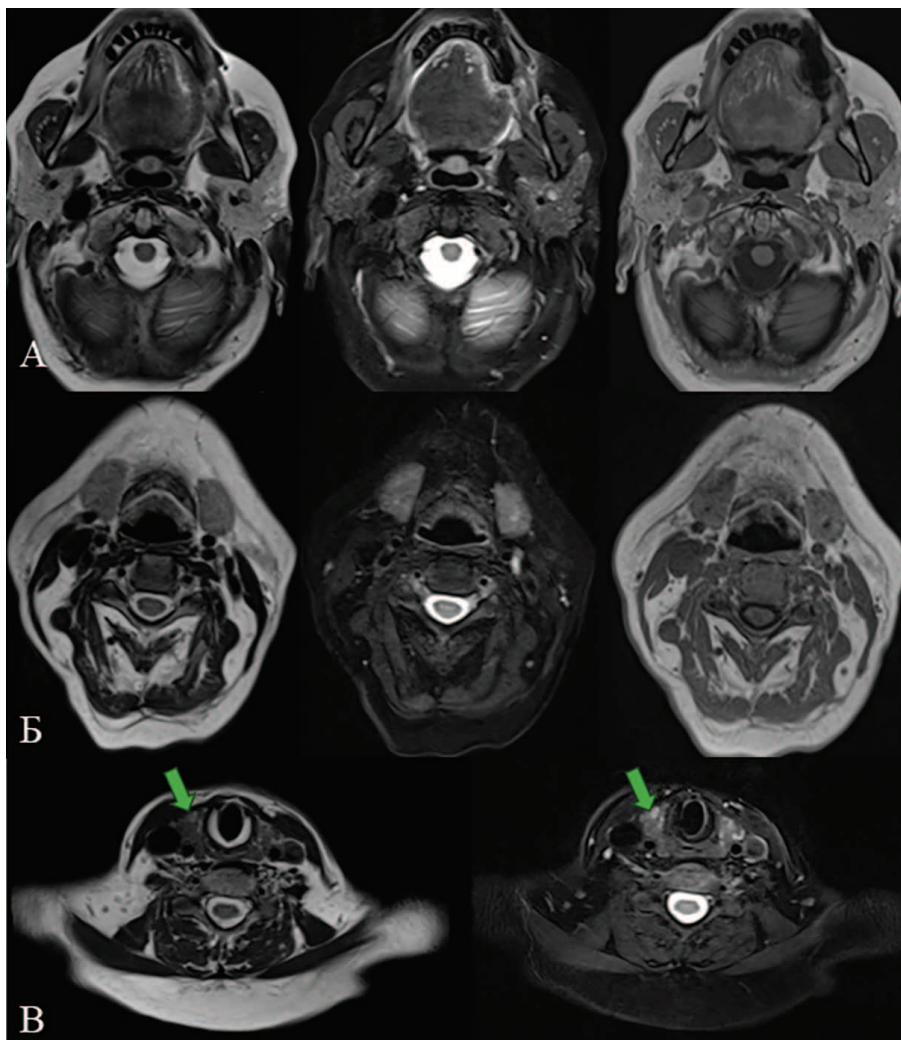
MRI of the soft tissues of the neck at the level of the parotid salivary glands (A), at the level of the submandibular salivary glands (B), at the level of the thyroid gland (C), T2-weighted image pulse sequences, T2-weighted image with signal suppression from fat tissue and T1-weighted image, axial projection: the salivary glands appear symmetrical, not enlarged, have clear contours and a uniform structure; a hyperintense nodule is visible in the right lobe of the thyroid gland (green arrow).
